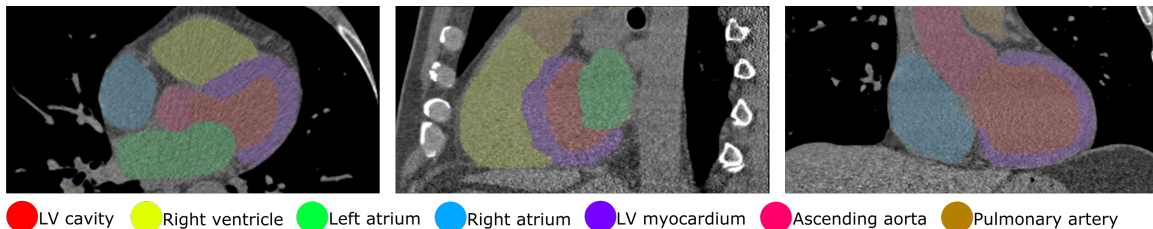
Automatic segmentation in a non-contrast CT image (secondary data set).
